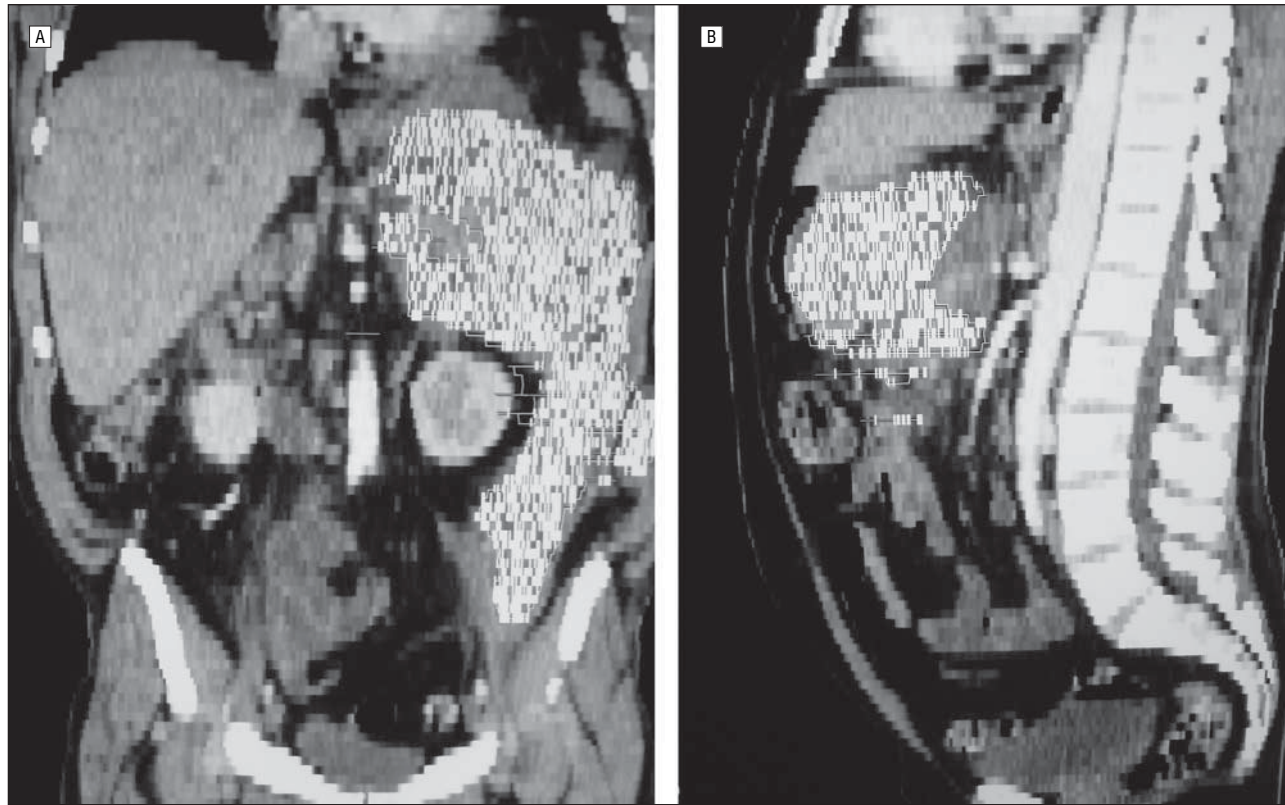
A patient with infected pancreatic necrosis. Anteroposterior (A) and profile (B) helical computed tomographic images.
